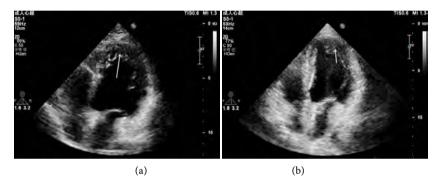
Echocardiography of the patient's 38- and 31-year-old daughters demonstrated a thickened and reticulated trabecular muscle (arrows) in the apex of left ventricle (a and b).
